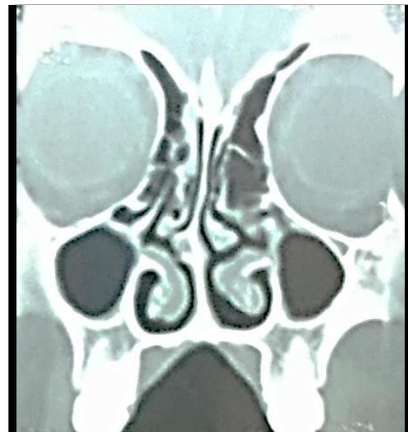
CT scan showing horizontal uncinate process and enlarged ethmoid bulla left with mild mucosal thickening in ethmoid infundibulum.
